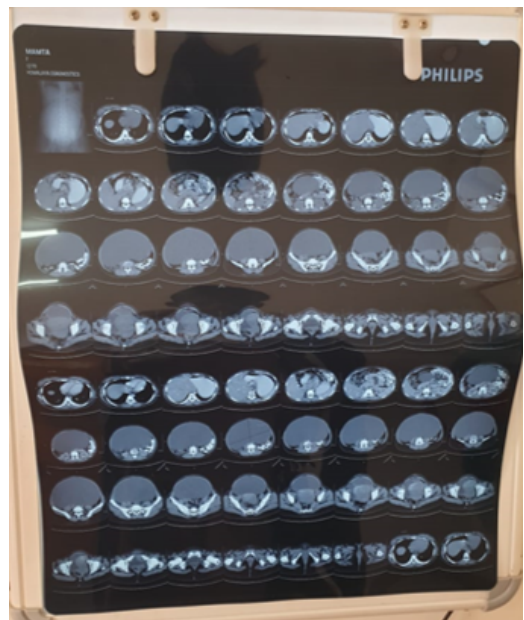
CT scan showing right ovarian cystic mass with no evidence of solid enhancing foci within the lesion.
